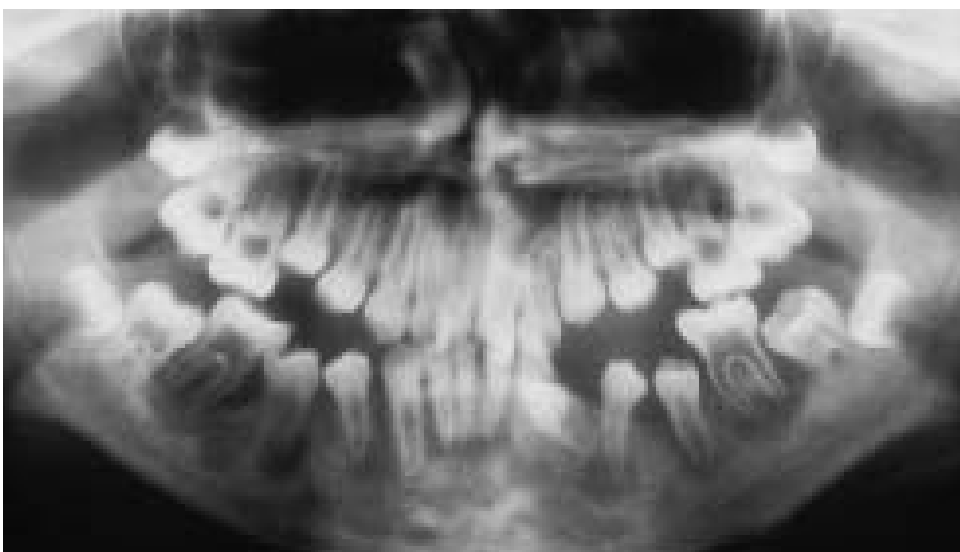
Orthopantomogram after extraction of primary teeth.
